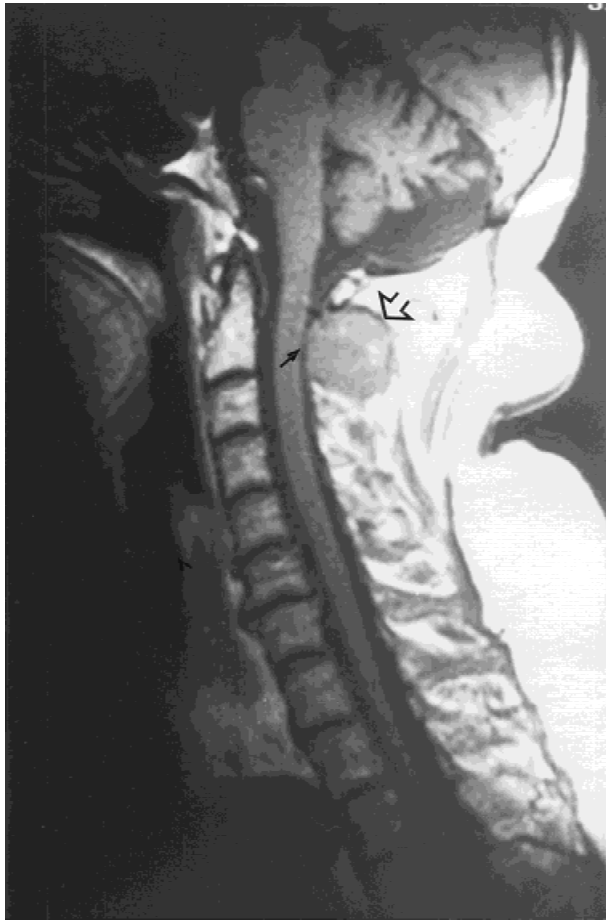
T<sub>1</sub>-weighted sagittal MRI image of the craniocervical junction. Round soft tissue mass (open arrow) at the level of C2 lamina, causing pressure on the posterior aspect of the cervical spinal cord (small arrow).
